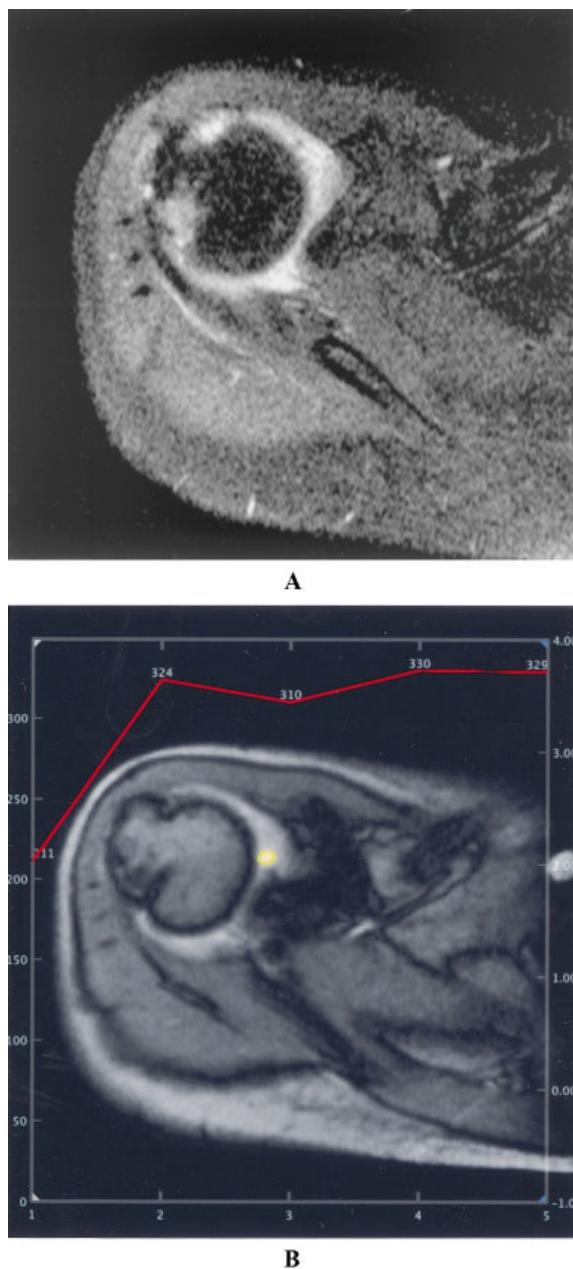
Dynamic contrast-enhanced magnetic resonance imaging of the shoulder joint of the same patient as in Figure 1. A, The transverse T1-weighted spin-echo sequence with fat saturation, after intravenous administration of gadolinium diethylenetriaminepentaacetic acid, reveals pronounced enhancement of erosions and the entire joint space, suggesting hypervascularized synovitis. B, The T1-weighted gradient-echo sequence with superimposed signal intensity–time curve shows in a circular region of interest (yellow area) a rapid increase in signal and an early transition to a plateau phase.
